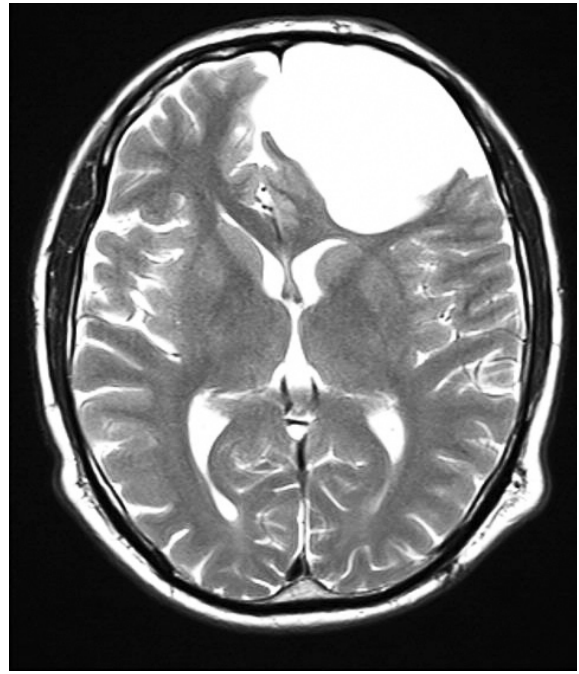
T2-weighted magnetic resonance image showed a hyperintense cystic lesion.
